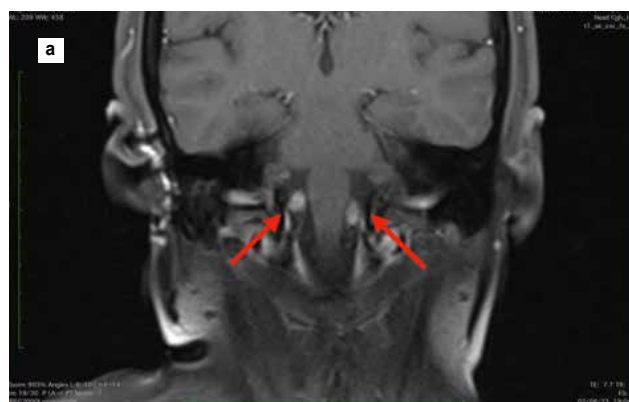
a and b. MRI T1 coronal contrast (a) and T2 axial (b) showing two well-defined enhancing lesions in lateral cerebellomedullary cisterns suggestive of hypoglossal schwannoma.
